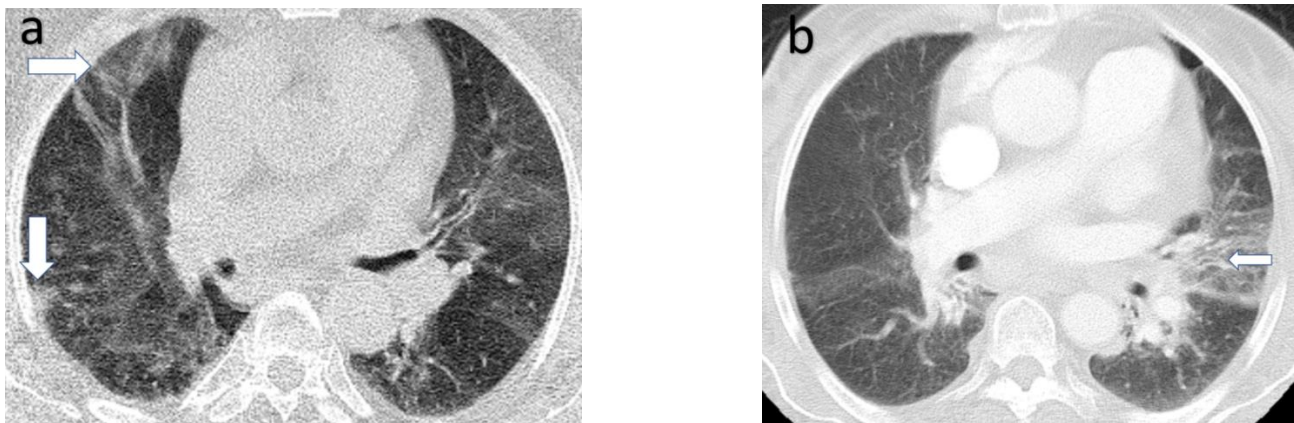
a: An 81-year-old man with a positive RT-PCR test. Chest CT shows bilateral, peripheral, amorphous ground-glass lesions with well-defined margins in the non-dependant region of right upper and lower lobes (arrows)
